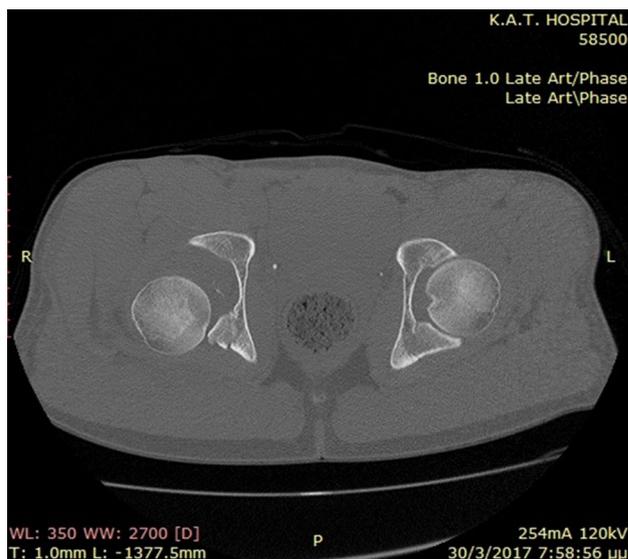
Computed tomography of the pelvis: axial view showing a fracture of the posterior wall of the acetabulum
